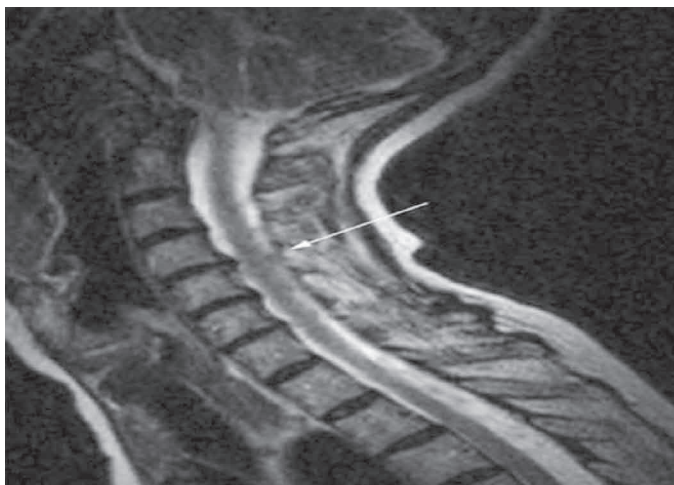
Cervical MRI Showing Cervical Stenosis (Not from Actual Patient).
